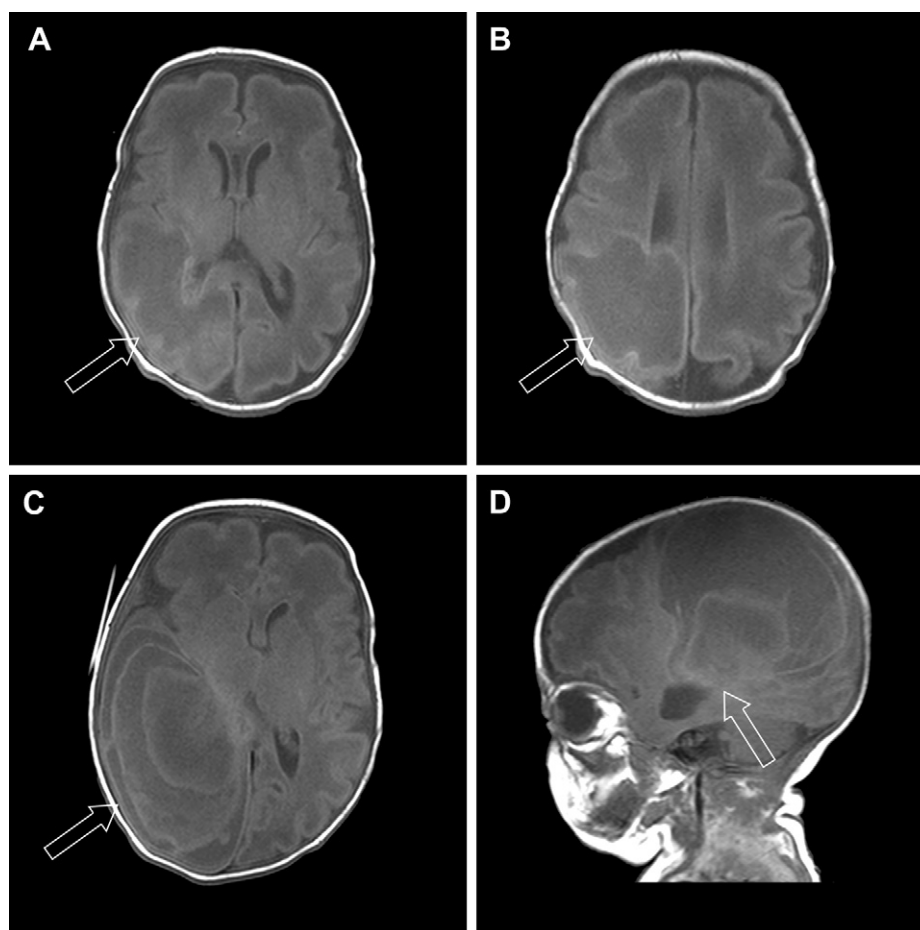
Preoperative magnetic resonance imaging of the brain showing: (A and B) right occipito-parietal brain abscess without midline shift; (C) increase in the size of the abscess with midline shift to the left; (D) right uncus herniation and a dilated right temporal horn suggesting entrapment.
